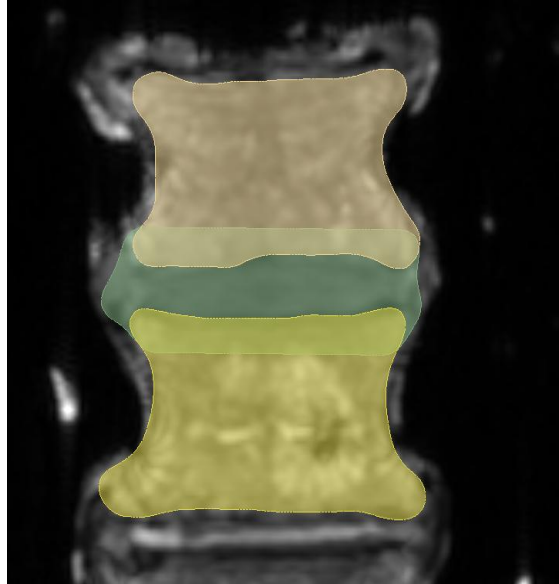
nucleus segmentation from MRI images
